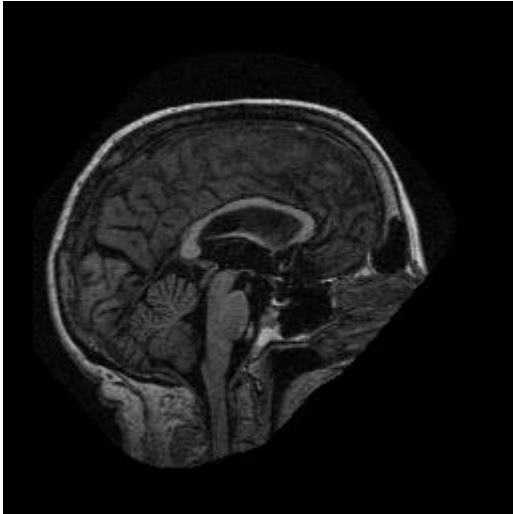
A representative noisy MR image of a non-AD test subject
